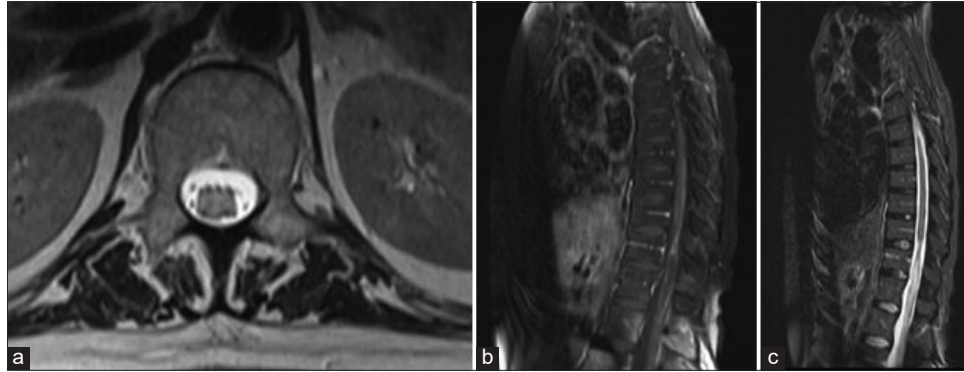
Preoperative magnetic resonance imaging. (a) Axial T2/STIR-weighted image, sagittal T1 and T2/STIR-weighted image, (c) sagittal T2/STIR-weighted showing the intramedullary abscess hypointense on images (a and b) and hyperintense on image (c).
